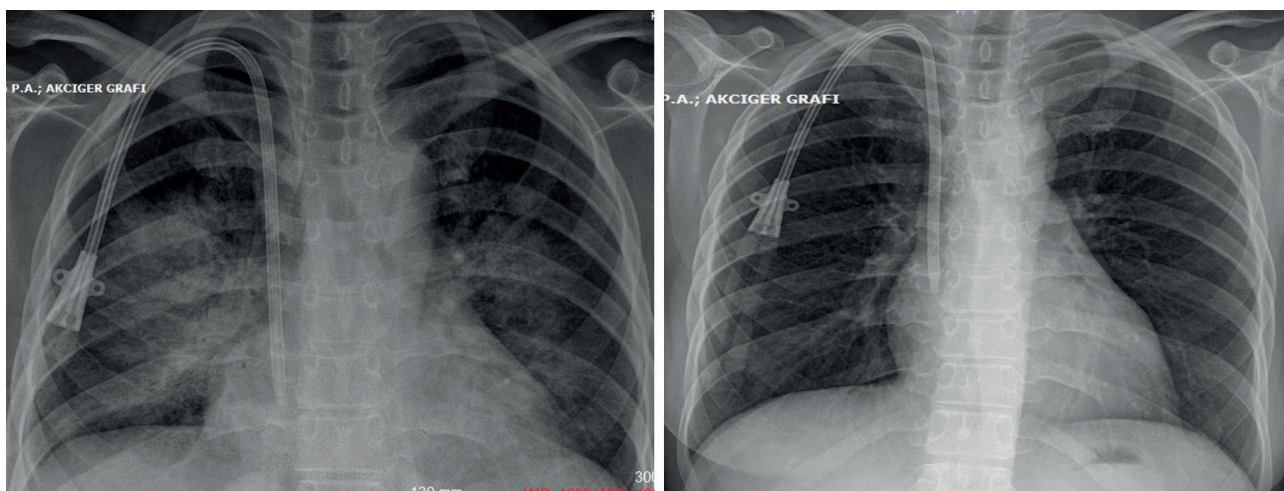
Posteroanterior chest radiographs taken during the active period of alveolar hemorrhage and two weeks later.
